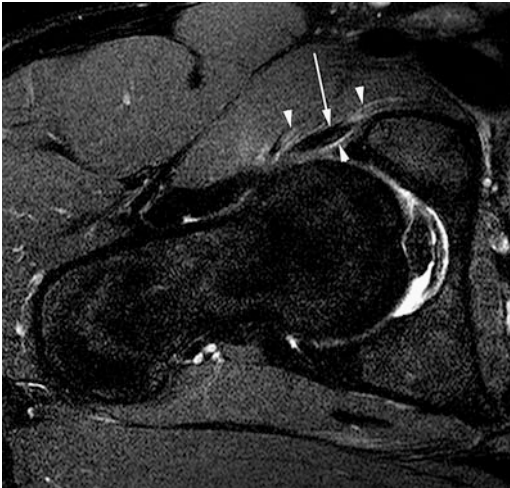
T2-weighted fat-saturated axial TSE sequence of a 22-year-old male patient (TR 3,641 ms/TE 62 ms, slice thickness 3 mm) shows an iliopsoas tendinitis with increased peritendinous signal (*white arrowheads*) around the iliopsoas tendon (*white arrow*). The iliopsoas tendon shows an increased signal within the tendon structure
